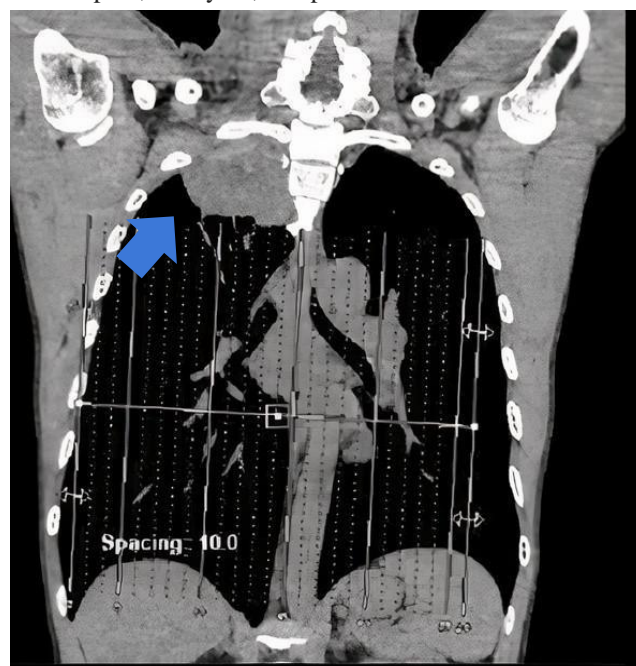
Coronal contrast CT-Scan, solid lesion with spiculated irregular edges in the right apical segment of the superior lobe of the lung
